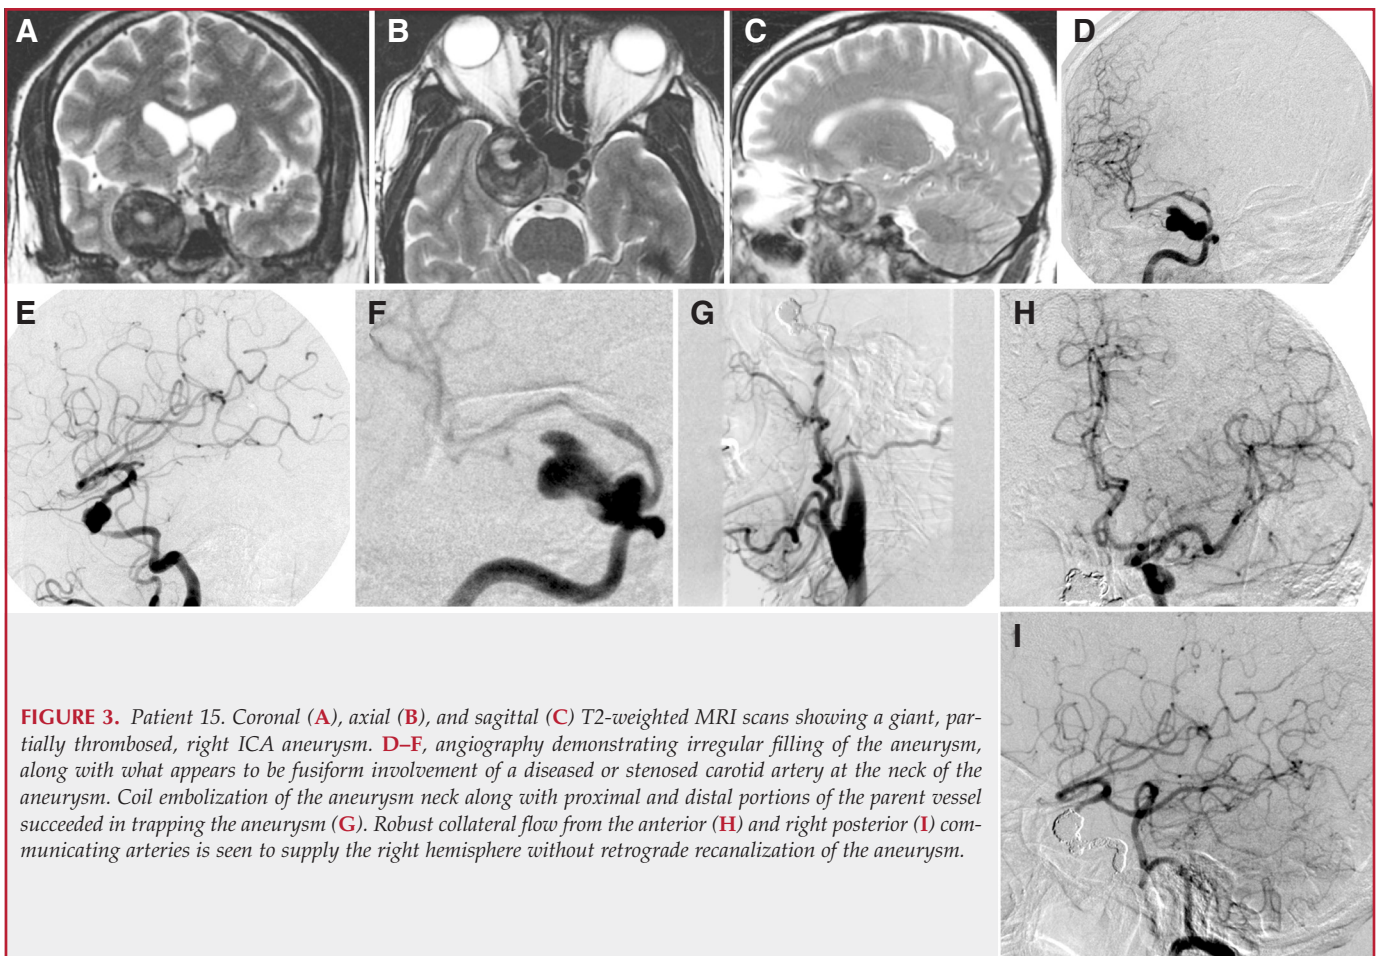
Patient 15. Coronal (A), axial (B), and sagittal (C) T2-weighted MRI scans showing a giant, partially thrombosed, right ICA aneurysm. D–F, angiography demonstrating irregular filling of the aneurysm, along with what appears to be fusiform involvement of a diseased or stenosed carotid artery at the neck of the aneurysm. Coil embolization of the aneurysm neck along with proximal and distal portions of the parent vessel succeeded in trapping the aneurysm (G). Robust collateral flow from the anterior (H) and right posterior (I) communicating arteries is seen to supply the right hemisphere without retrograde recanalization of the aneurysm.
